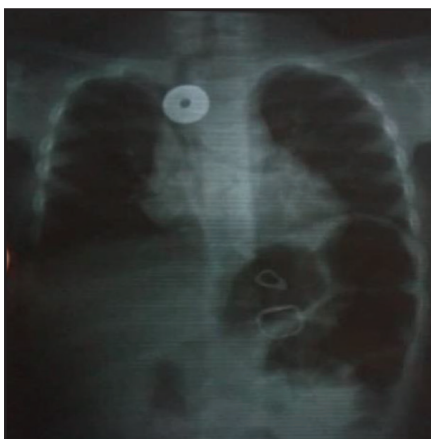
Chest X-ray showing the location of metallic foreign body
